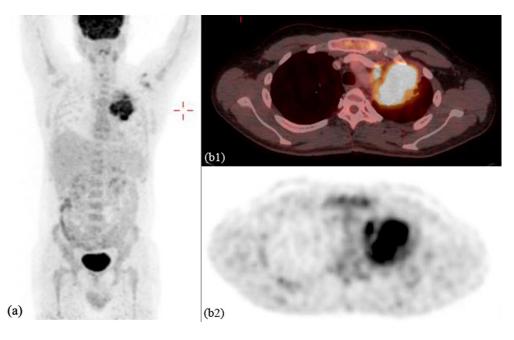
(a) Maximum intensity projection coronal image showing F-18 fluoro-deoxy-glucose (FDG) uptake by the left lung mass lesion (max SUV-8.7).
